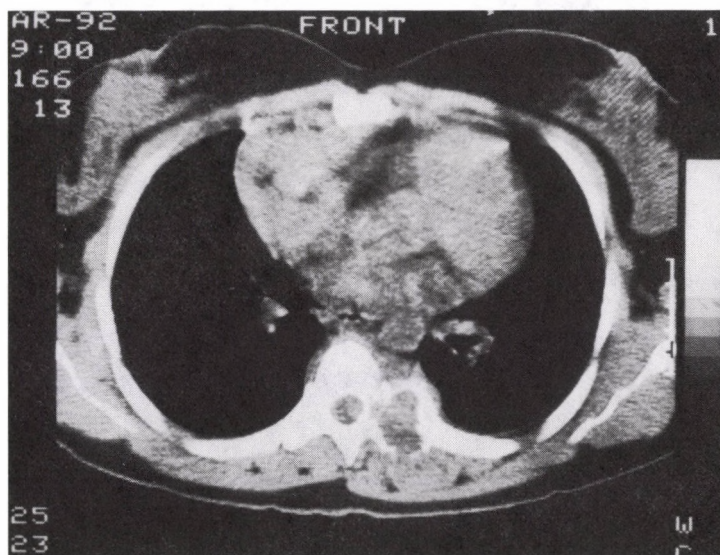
The large mediastinal tumour caused by Hodgkin's disease was well seen on conventional X-ray examination. CT discovered surprisingly the lytic destruction of the costotransversal process of the VIth thoracic vertebra with an adjacent part of the rib
